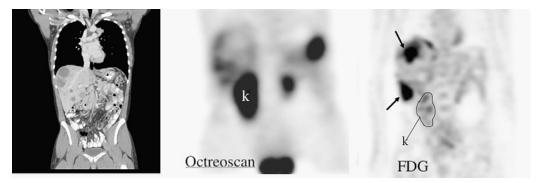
Example of a patient with dedifferentiated carcinoid tumor liver metastases depicted on CT that do not concentrate, or minimally concentrate, in In -111 pentetreotide. In contrast, these tumors are strongly fluorodeoxyglucose avid on positron emission tomography (*arrows*). k, kidney.
